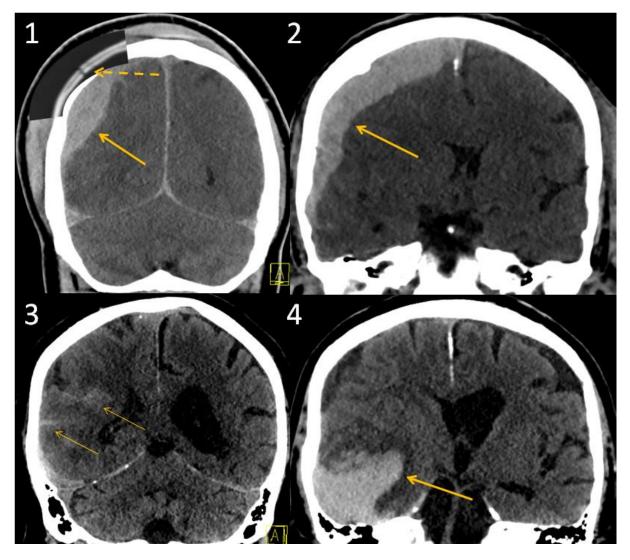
Head CT (coronal plane) following TBI; 1: Skull fracture (arrow with spaced lines) and epidural hematoma (EDH) (arrow); 2: Subdural hematoma (SDH) (arrow); 3: Traumatic subarachnoid hemorrhage (t-SAH) (arrows); 4: Contusion hematoma (arrow). Courtesy of Neuroradiology department (OUS-Ullevål). With permission.
